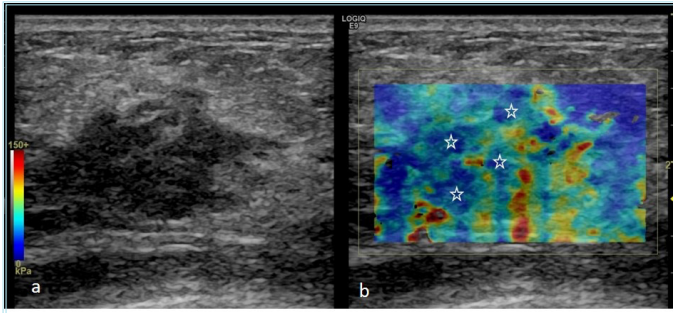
In a patient diagnosed with idiopathic granulomatous mastitis, a hypoechoic patchy area is observed on gray-scale ultrasound (a), and free-hand elastography reveals that the lesion predominantly consists of soft areas coded in blue (stars). In contrast, malignant masses typically appear as stiffer structures on elastography
